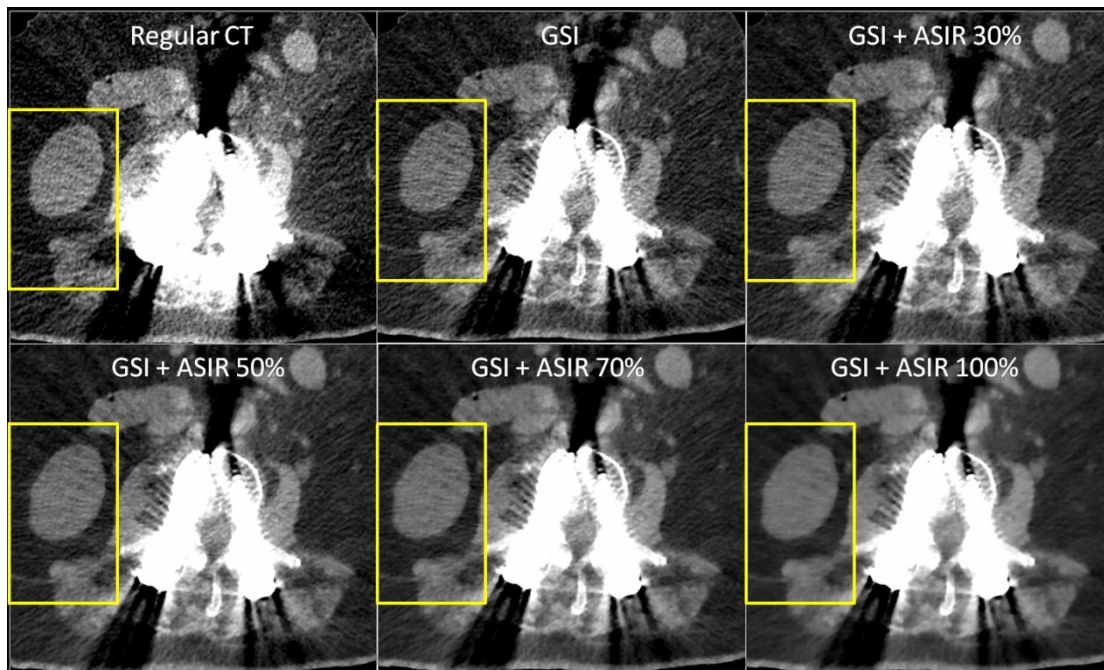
Effects of various blending levels of ASIR with GSI for evaluation of a 60-year-old male with lumbar internal fixation for disk herniation. The screws generated remarkable metal artifacts in regular CT, which were significantly reduced by the GSI technique. However, the GSI scan still had noisy soft tissue images (indicated by the right kidney and surrounding muscles within the rectangle box). By adding increasing levels of ASIR to GSI, image noise was gradually reduced, and the appearance of tissue structure became smoother. Please note that all CT images were reconstructed from one GSI scan.
